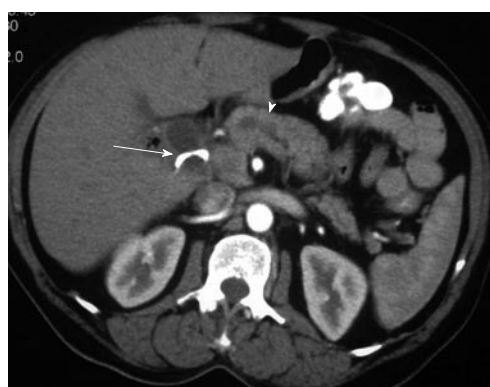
Computed tomography showing dilated common bile duct with stent in it (arrow) and dilated main pancreatic duct (arrowhead); no definite mass could be visualized.
